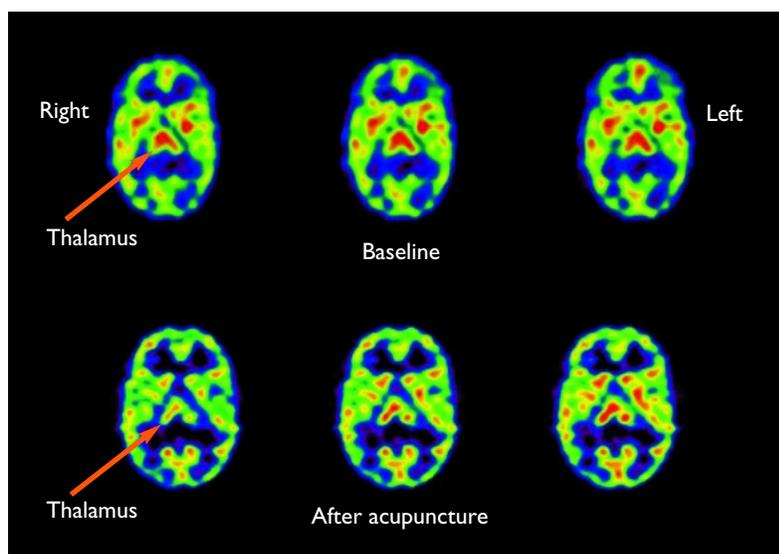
Brain single photon emission computed tomography (SPECT) images demonstrating cerebral blood flow changes in the brain between the baseline state with pain and post-acupuncture, when the pain was relieved. Red indicates the highest activity level, followed by yellow, blue, and black (in descending order). With pain (ie, baseline), thalamic activity is initially asymmetric, with activity on the left side greater than on the right. After acupuncture, the thalamic activity has shifted, with activity on the right side now greater than on the left.
